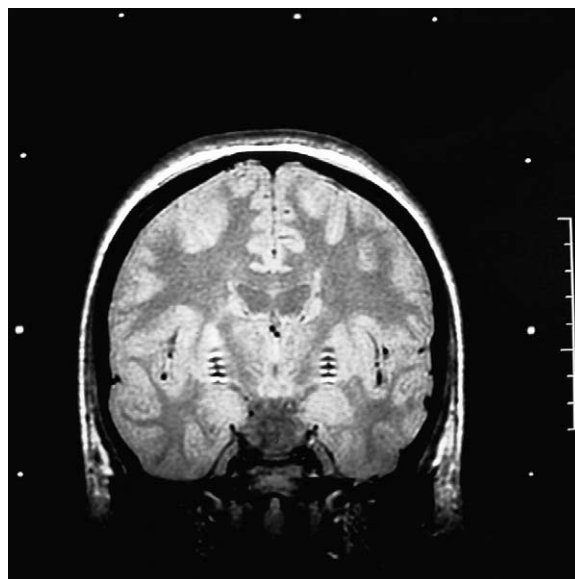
Example of an MRI showing Medtronic 3387 lead electrodes positioned in the Gpi. This MRI was obtained from a patient from another European country because as a result of legislation in The Netherlands, we could not obtain it from the patient described in this report.
